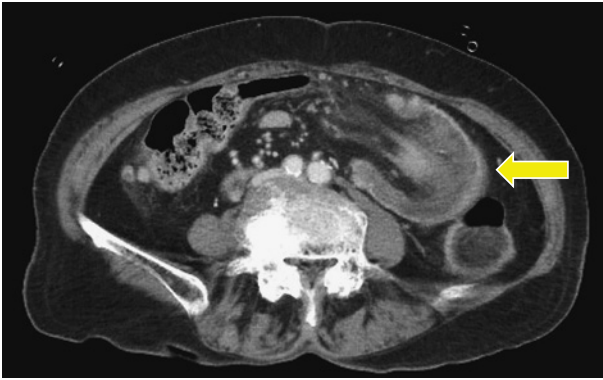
Abdominal contrast CT scan intussusception with the transverse colon tumor was observed as the presenting part, while the fatty tissue concentration around the tumor was elevated.
